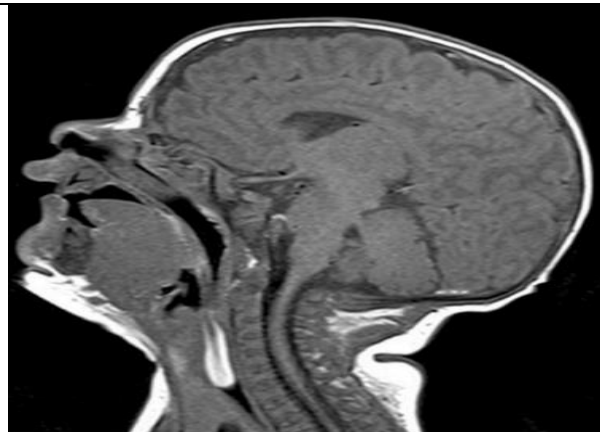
A sagittal T1-weighted MRI scan shows an elongated polypoid mass spreading from the throat to the esophageal opening.
